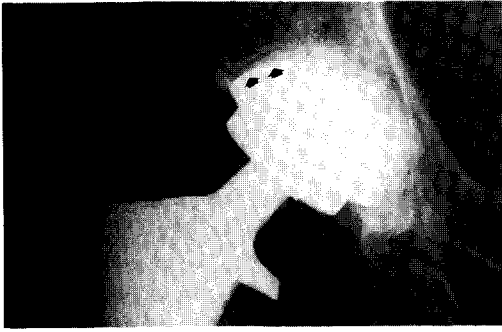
Anteroposterior radiograph of metal on metal total hip replacement at 3 years postoperative with with nonprogressive radiolucent line (arrows) observed immediately postoperatively in Zone 1 of the acetabular component.
